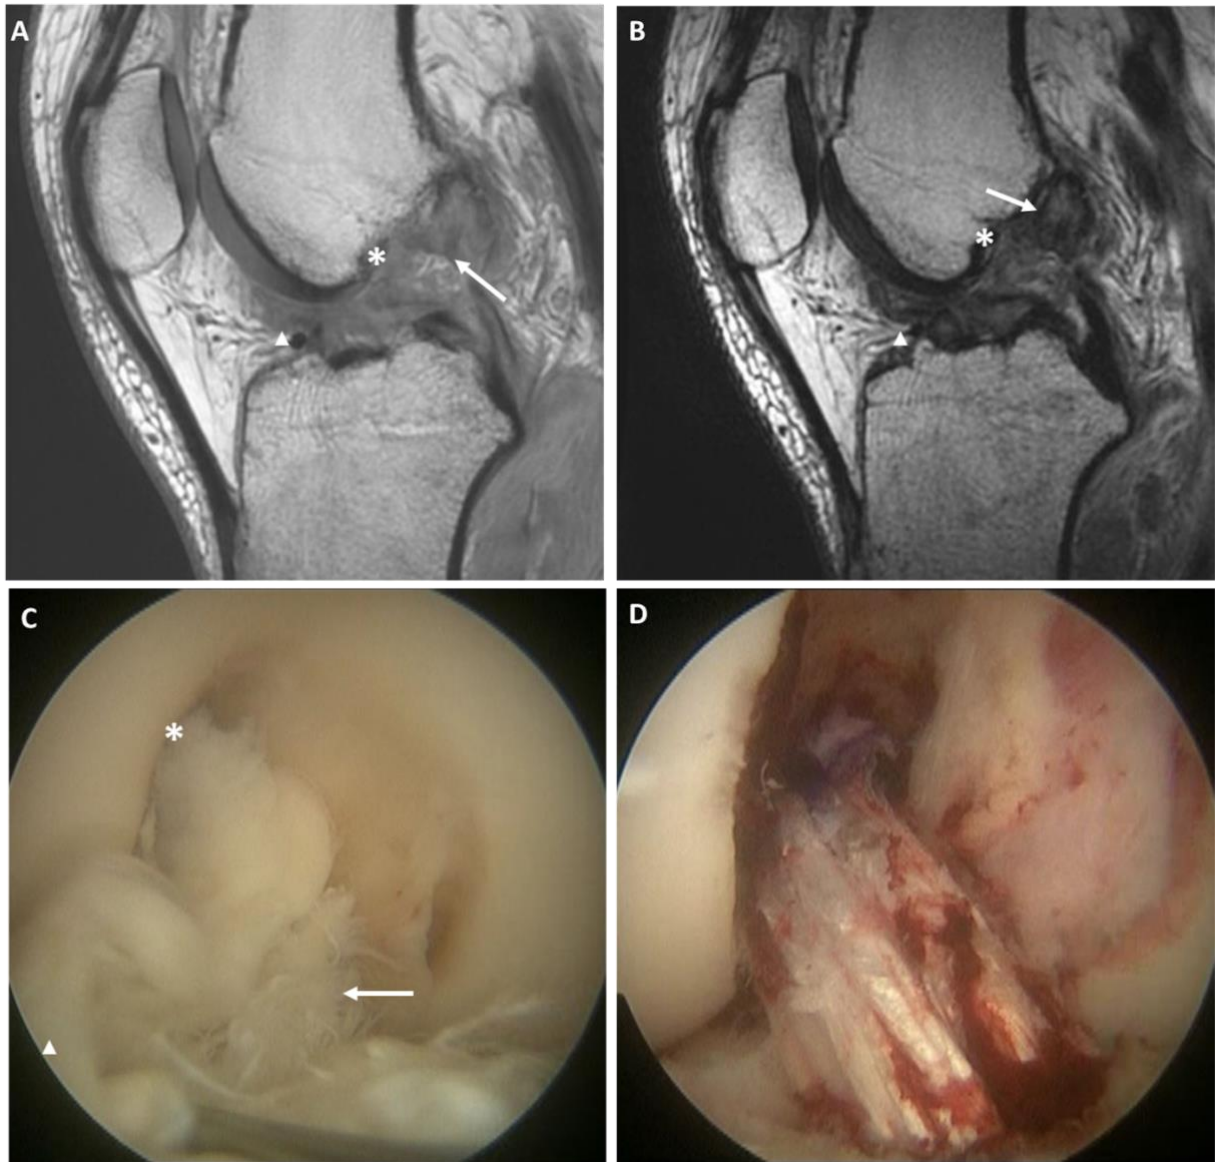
Sagittal T1 (A) and T2 (B) views show a type II proximal tear (arrows) with good tissue quality (asterix). Arthroscopy with probing (asterix) confirms that sufficient tissue length for primary repair is present (C). Some fibers of the posterolateral bundle are present on the femoral wall (D, arrow), which explains the discrepancy between a type II tear on MRI and a type I proximal avulsion tear on arthroscopy (asterix). Primary repair was performed and an InternalBrace was added.
